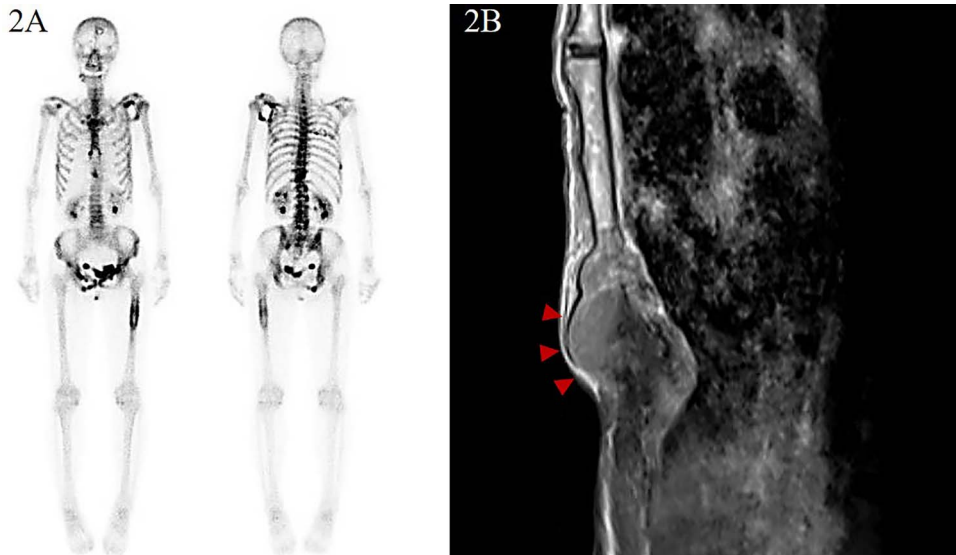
(A) PET-CT suspected multiple bone metastasis including frontal bone, mandible, left scapula, rib, vertebra, pubis, left femur and sternum; (B) MRI showed enhanced mass in the sternum.
